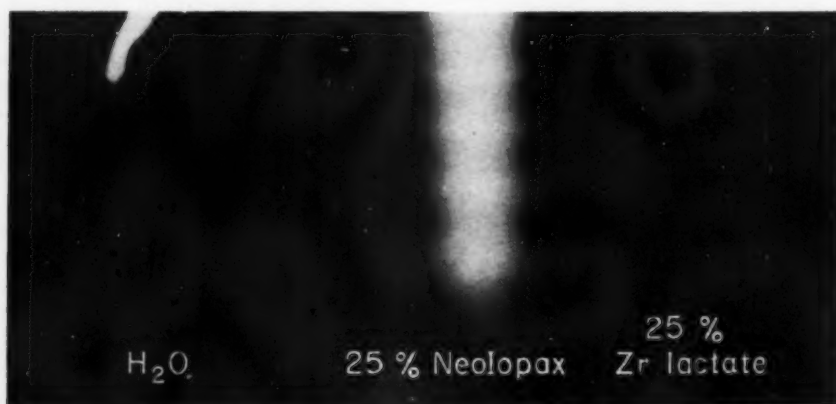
Radiograph of finger cots containing water, Neo-Iopax, and 25 per cent zirconium lactate, at 80 kvp. Note marked difference in density of the Neo-Iopax and the zirconium salt. The finger cot containing water is not visible at all.
